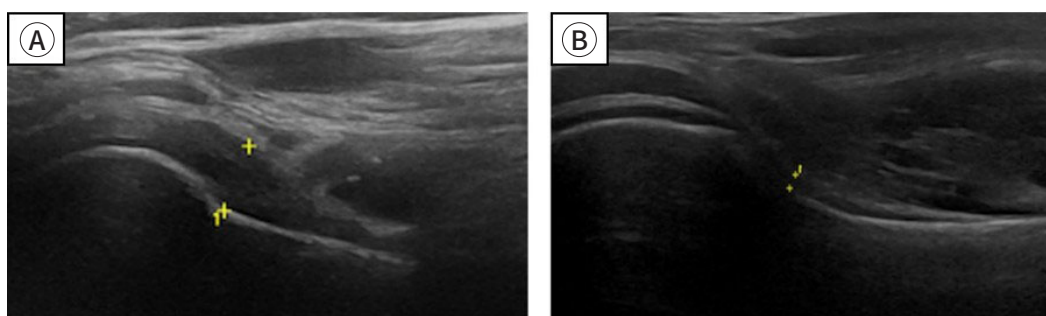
Ultrasonography, oblique axial section. Thickened axillary pouch (A), normal axillary pouch (B). Adapted from Tue et al. [17] with CC-BY.
